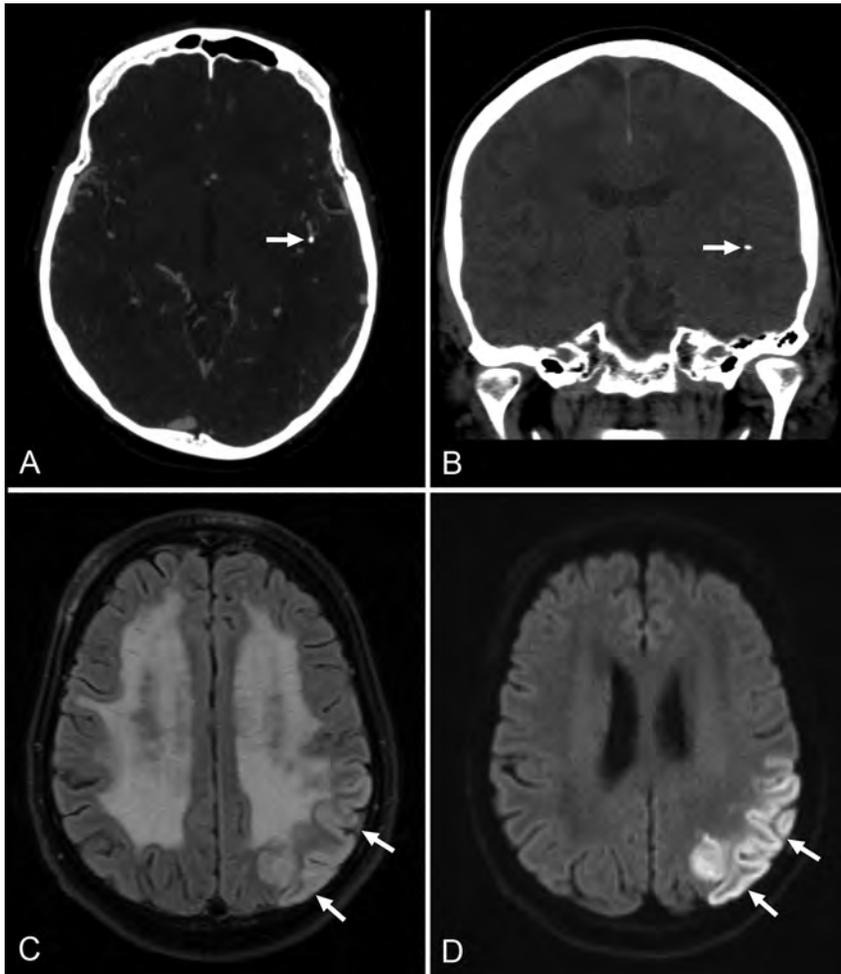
A 70-year-old male patient with acute ischemic stroke. At initial CTA evaluation, LVO due to a calcified embolus in the M2 segment of the left middle cerebral artery (arrows in CTA image, A; and in a noncontrast head CT image, B) was misinterpreted as clinically irrelevant calcification. Follow-up MR imaging (FLAIR image, C; and diffusion-weighted image, D) 1 day after CTA reveals infarction in the left middle cerebral artery territory (arrows).
